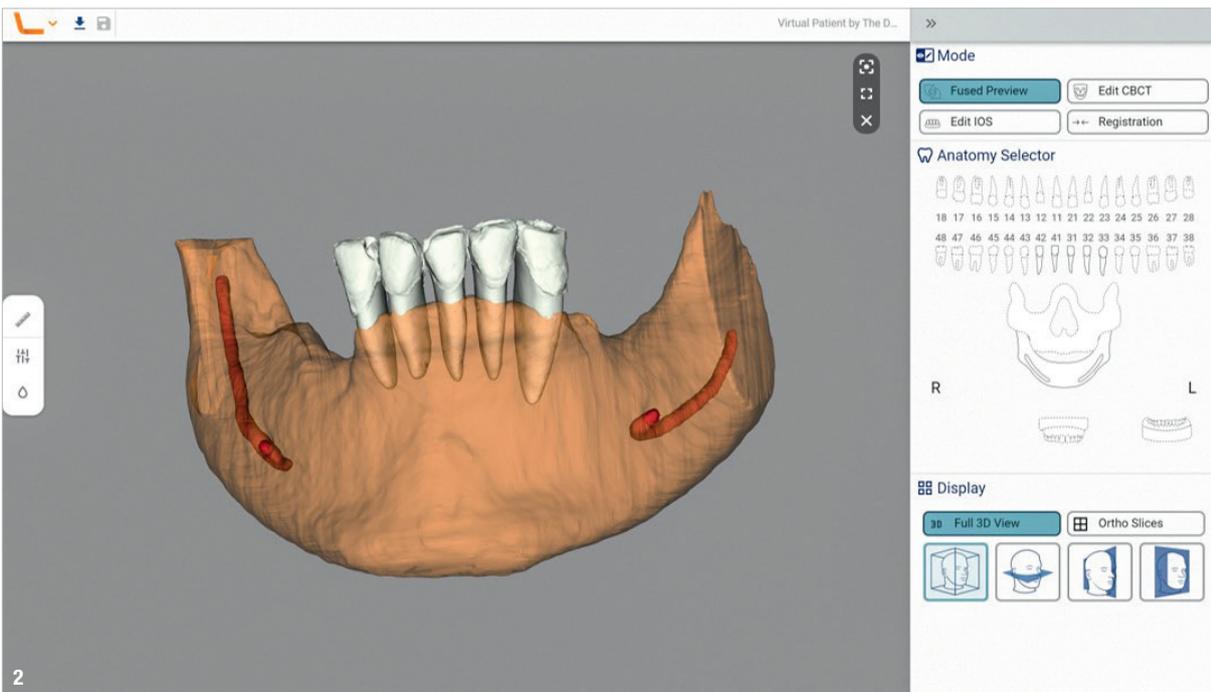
Fusion and automatic alignment and superimposition of 3D files from the intra-oral scan over the CBCT data.
